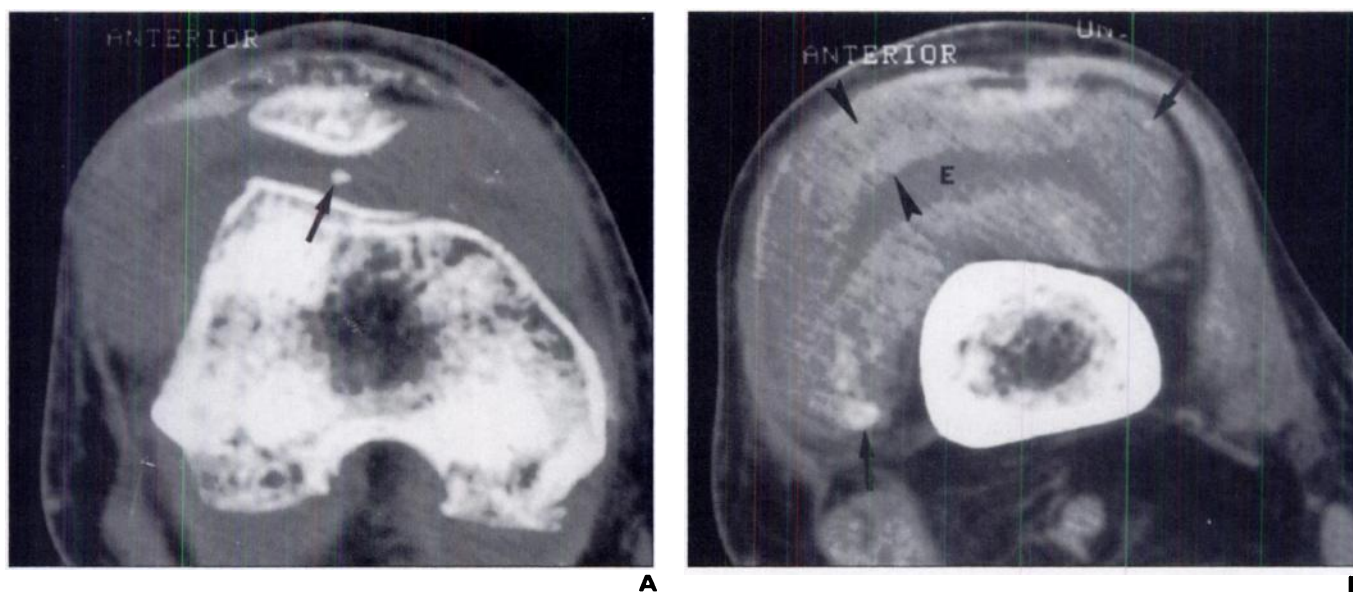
61-year-old man who presented with right knee pain. A and B, Axial CT scans of right knee at superior pole of patella (A) and supracondylar femur (B) show marked synovial thickening (arrowheads, B) with punctate superficial (arrow, A) and deep (arrows, B) calcifications. Joint effusion (E, B) is evident. Bones show no evidence of metastases.
